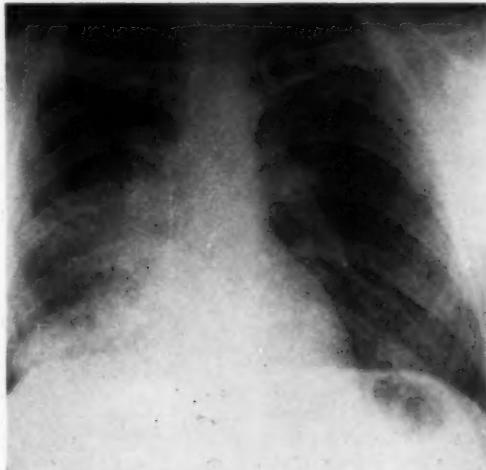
The admission x-ray shows a pneumonic infiltrate involving the right middle lobe and the superior segment of the right lower lobe.
